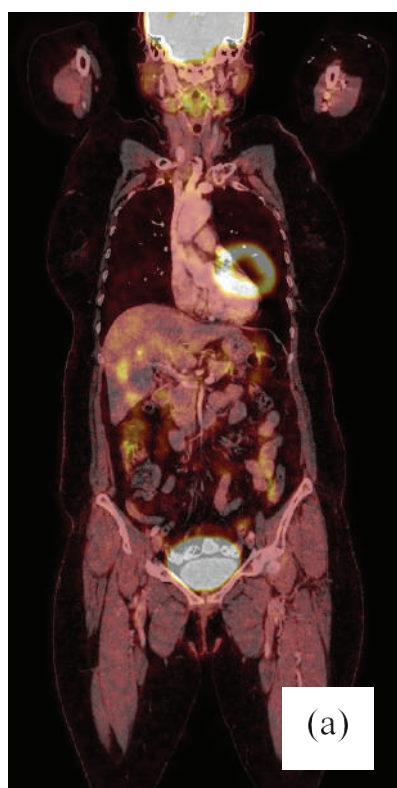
(a) CT image of a 70-year-old male patient with motion artifact, (b) Fused image of a 11-year-old pediatric patient with misregistration
